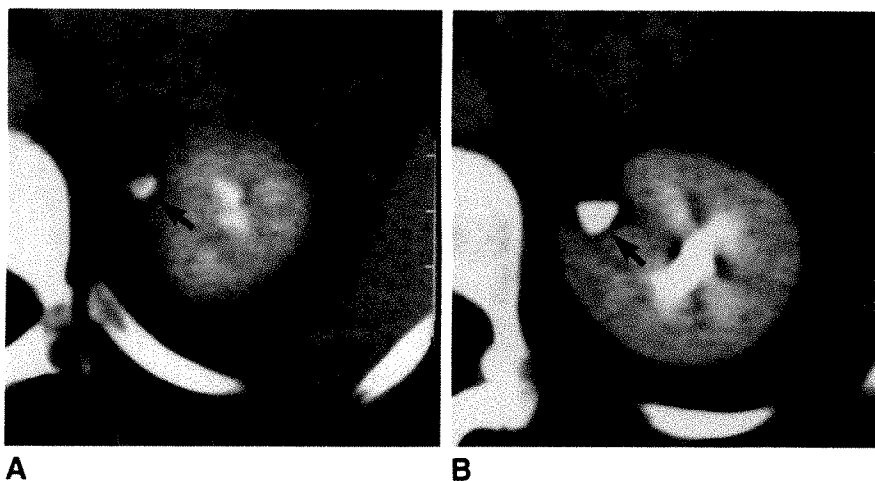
A and B, Enhanced CT scans show a medially located left-upper-pole ureter (arrows). Findings on excretory urogram and sonogram were normal.
